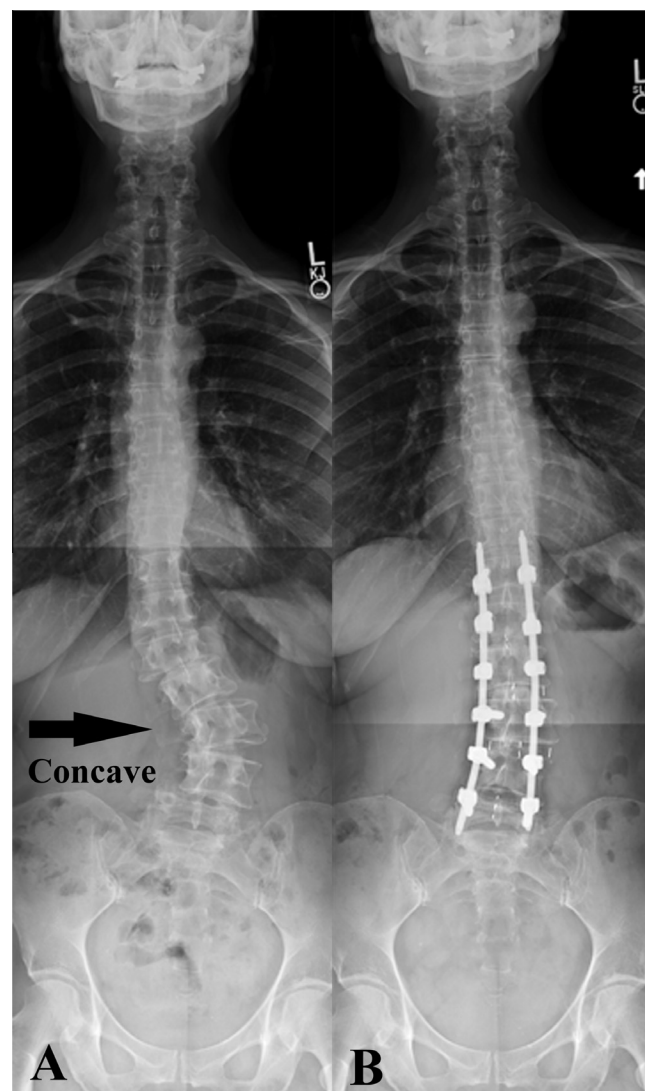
Antero-posterior radiographs, preoperative (A) and final follow-up at 13.3 months (B). The black arrow denotes the direct lateral interbody fusion approach from the concave side of the scoliosis curve.
